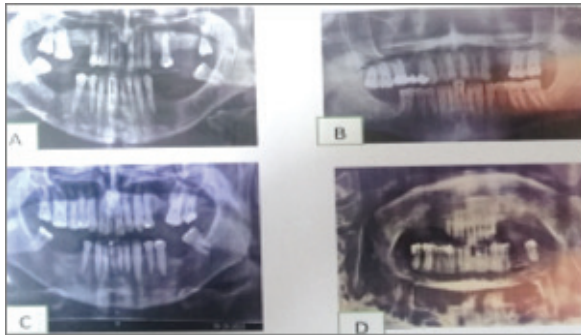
Panoramic radiographs detection are screening tools for osteoporosis.
